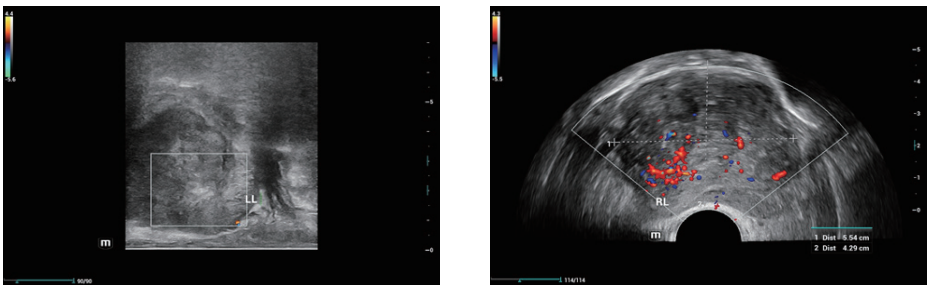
The 2D Ultrasound found a suspicious hypoechoic nodule with hypervascularity in the peripheral zone of the right lobe and irregular capsule
